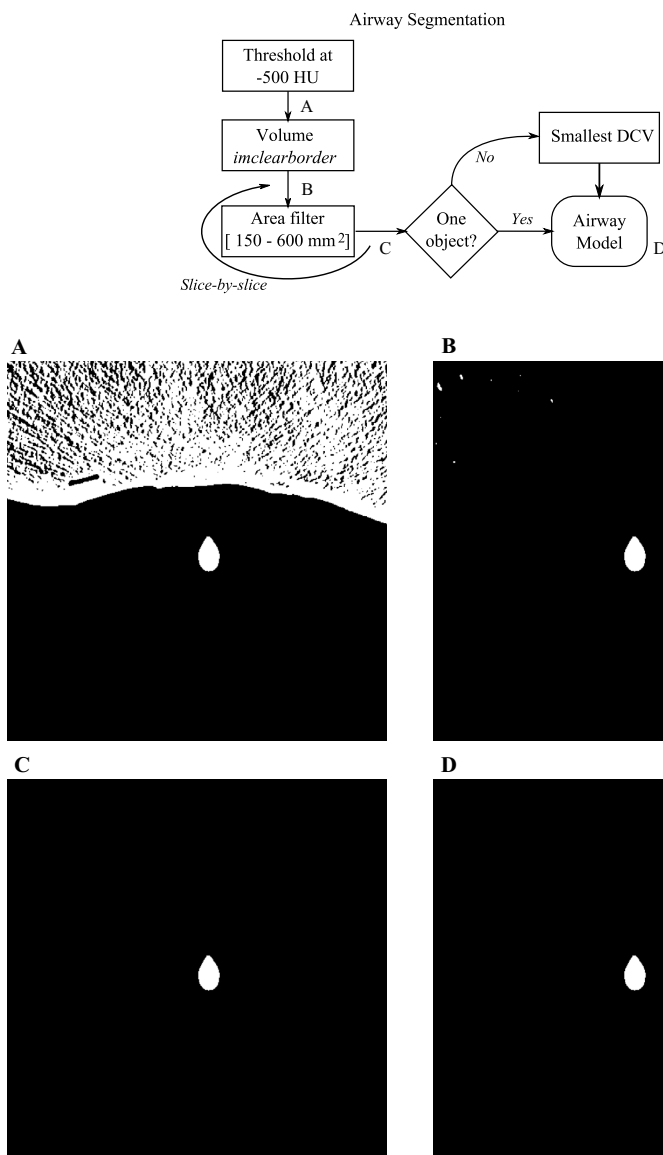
Two-step (airway detection and carotid identification) analysis scheme for carotid identification in CTA (example intermediate results A, B, C and D)
